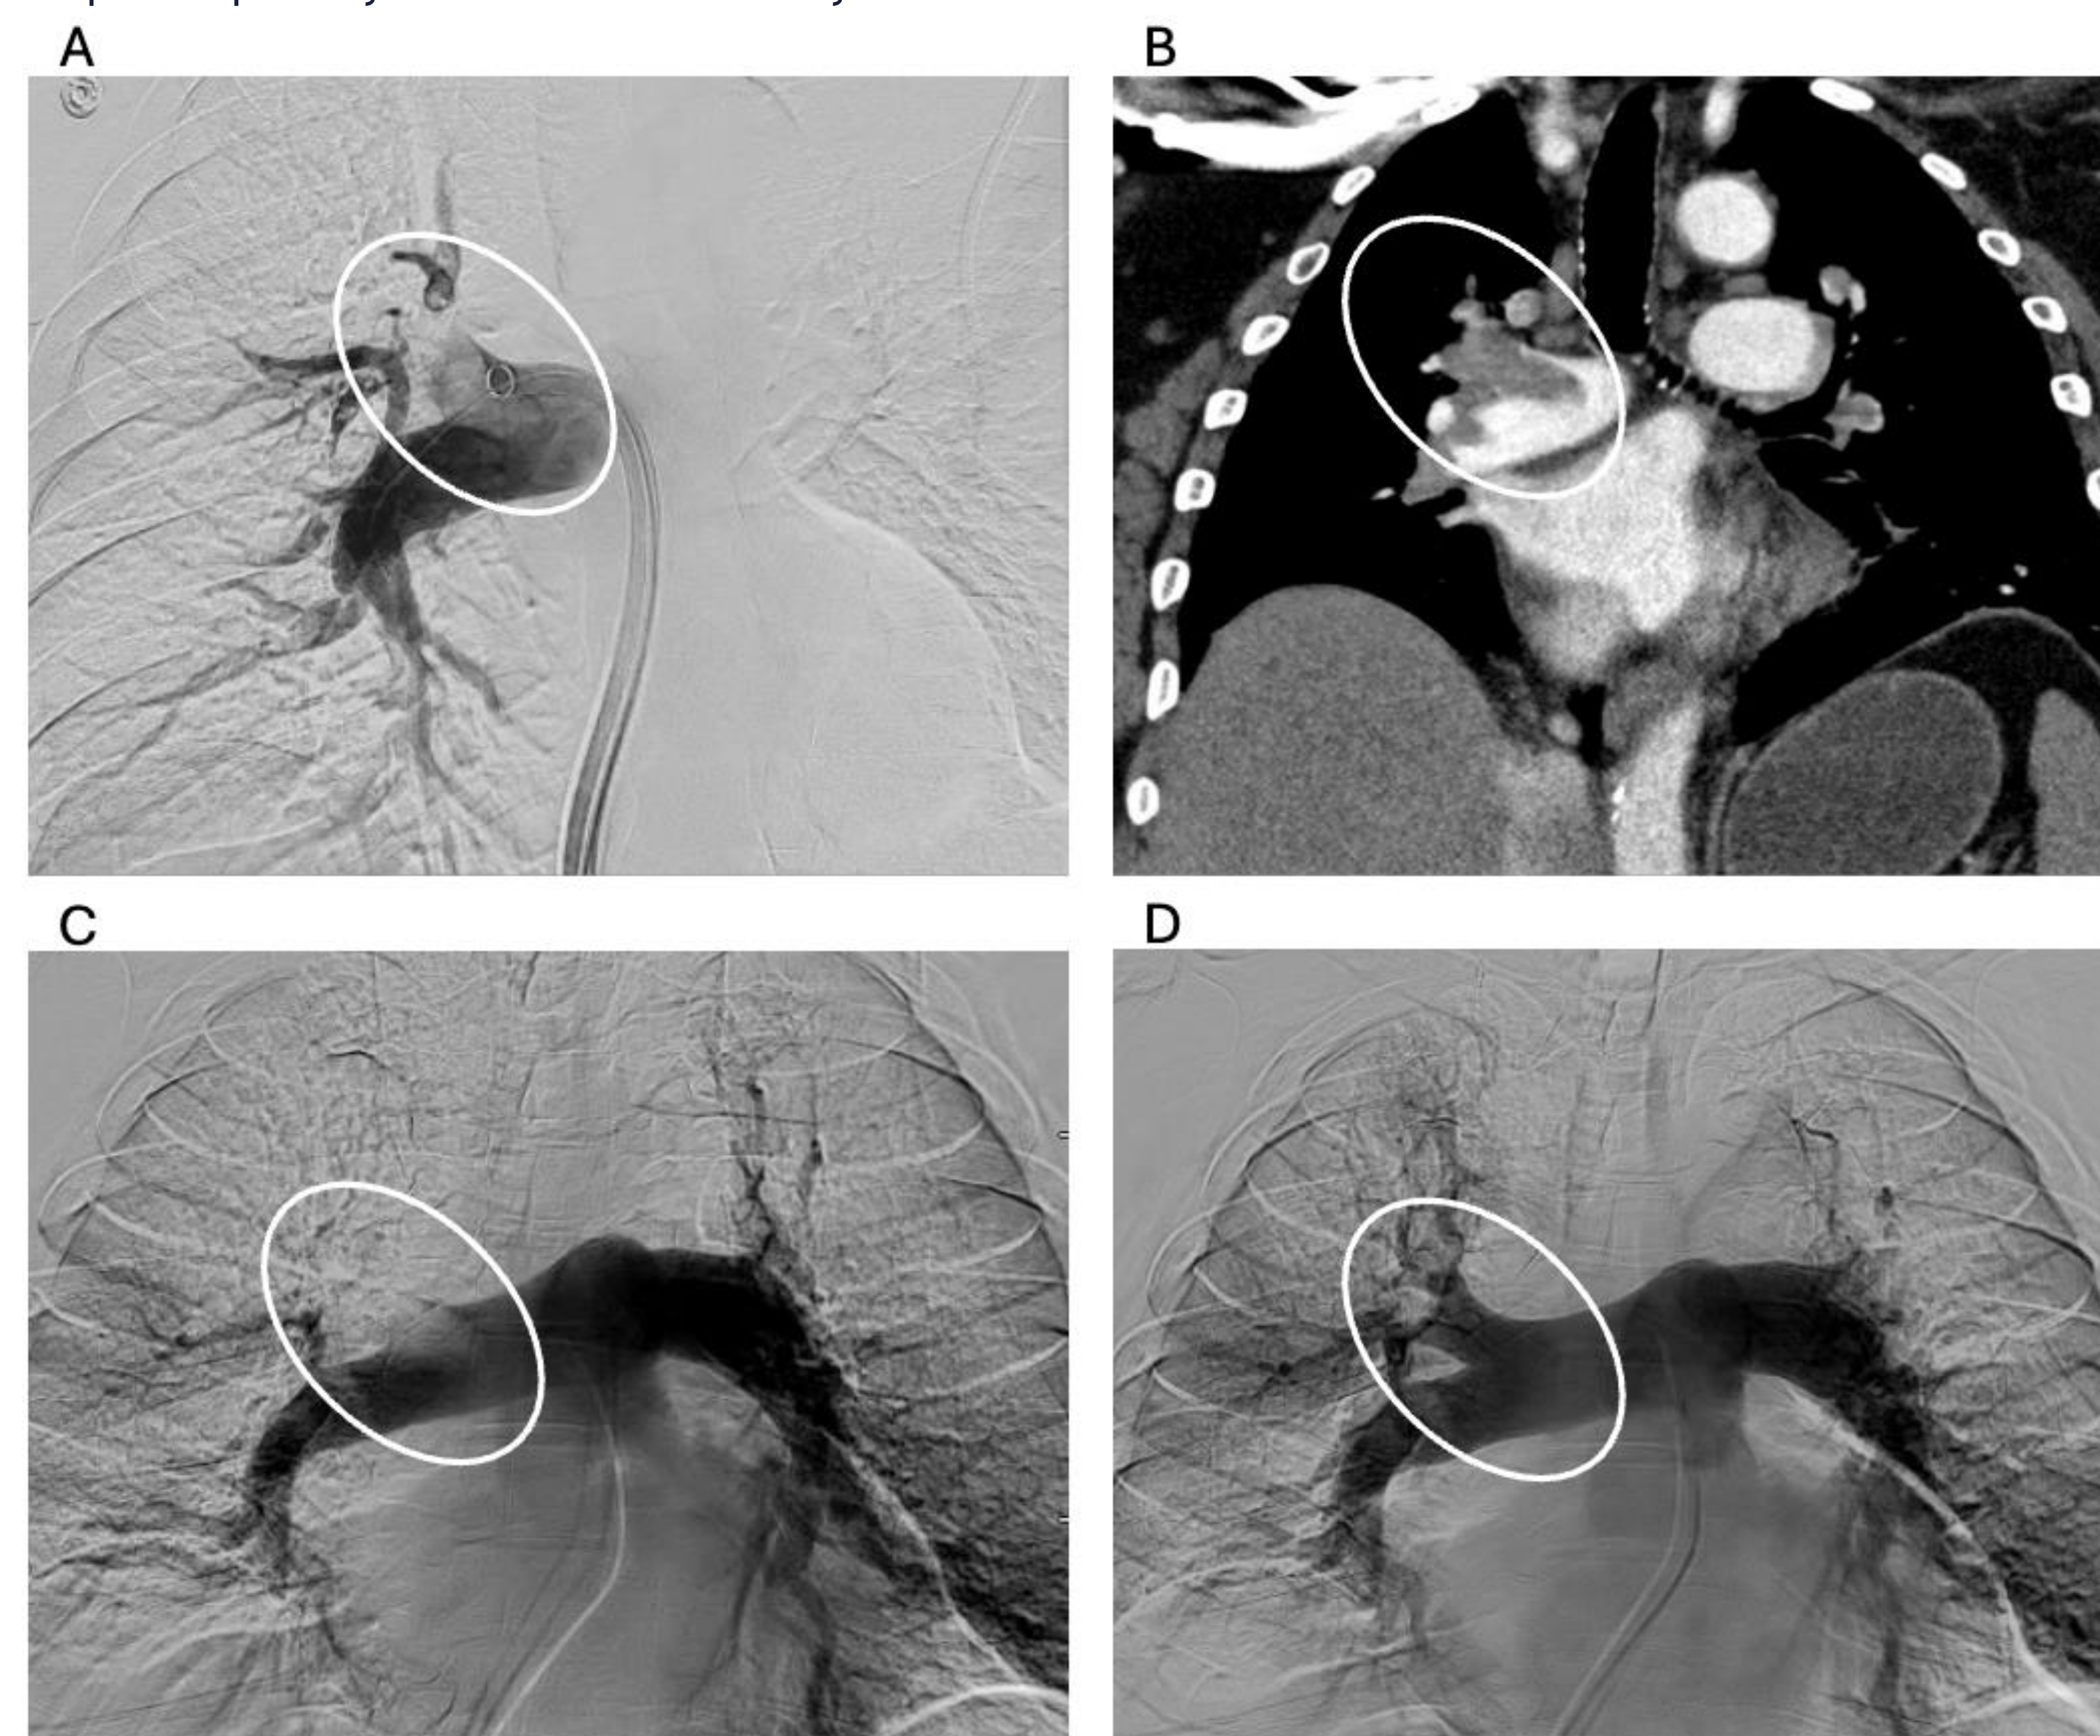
(A) Final fluoroscopic image from first thrombectomy procedure for patient in Case 2 showing filling defect in the truncus anterior. (B) CT coronal image after decompensation event showing similar thrombus. (C) Pre-second thrombectomy pulmonary angiogram showing similar filling defect in the truncus anterior. (D) Post-second thrombectomy showing improved patency in the truncus anterior.
